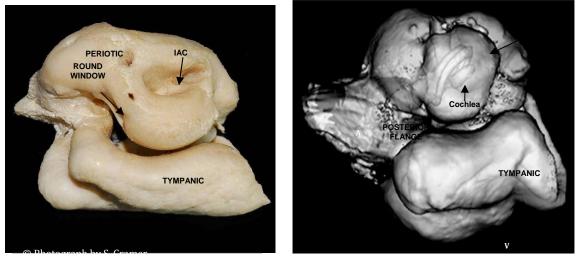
Photograph (left) and a 3D reconstruction (right) from CT scans of a left ear tympano-periotic from a bottlenose dolphin. medial view. The bone in the 3D is transparent to show the spiral cochlea in the periotic. The vertical shaft above the cochlea is the auditory nerve, which exits the periotic at the opening of the internal auditory canal (IAC on left).
